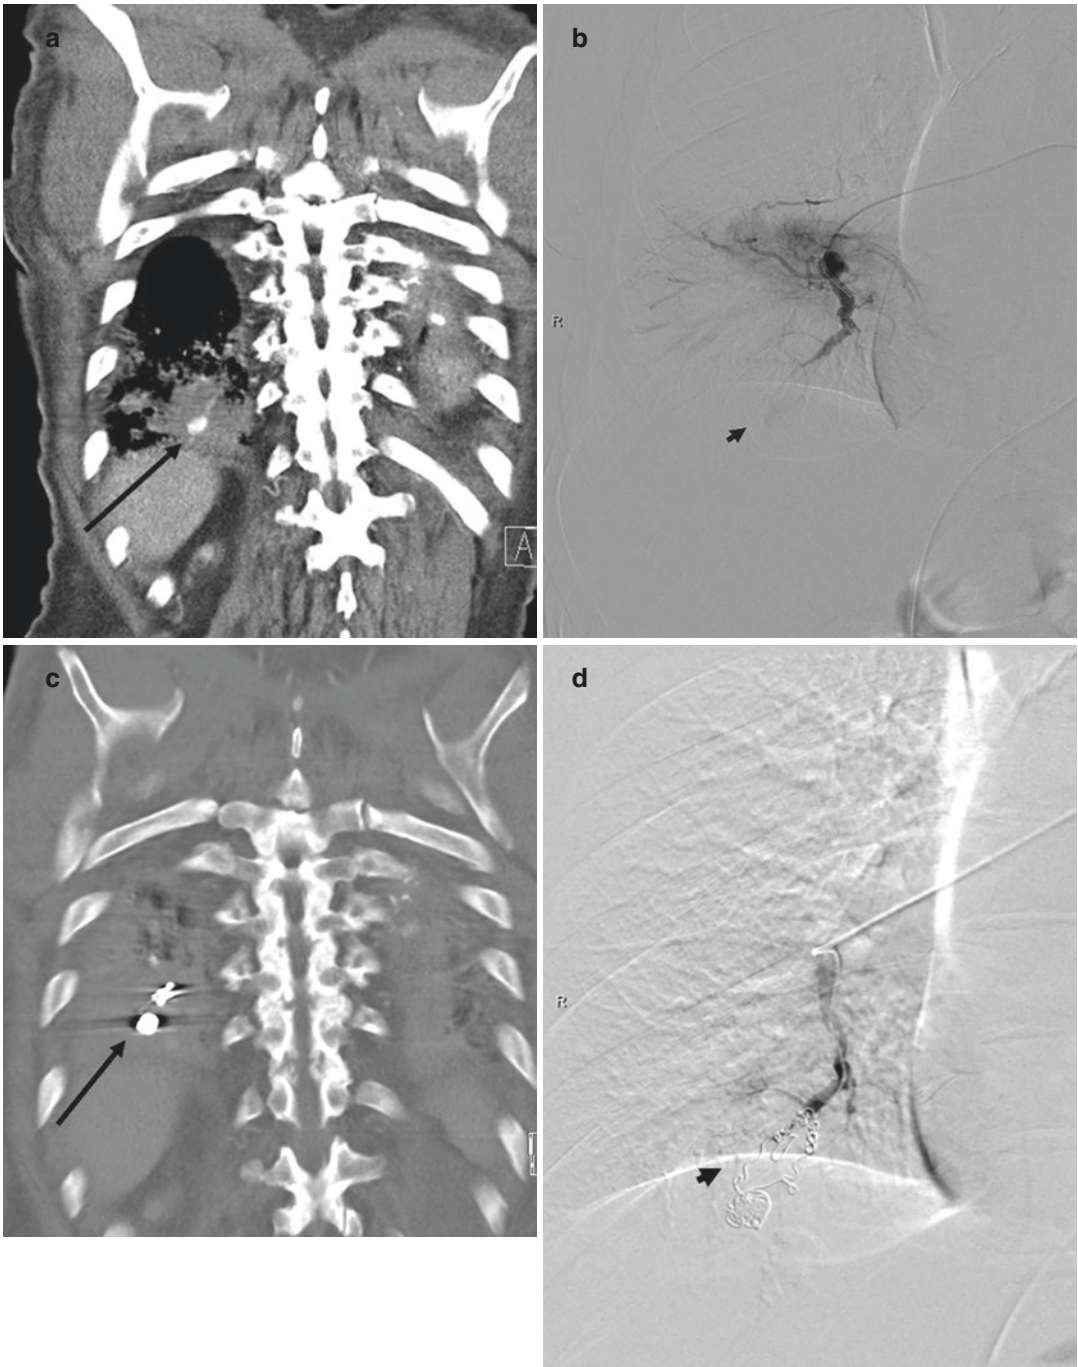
Rasmussen aneurysm in a 34-year-old man with post-primary pulmonary tuberculosis who presented with massive hemoptysis. (a) Coronal contrast-enhanced CT and (b) selective right pulmonary angiogram images show a small Rasmussen aneurysm arising from the distal right
